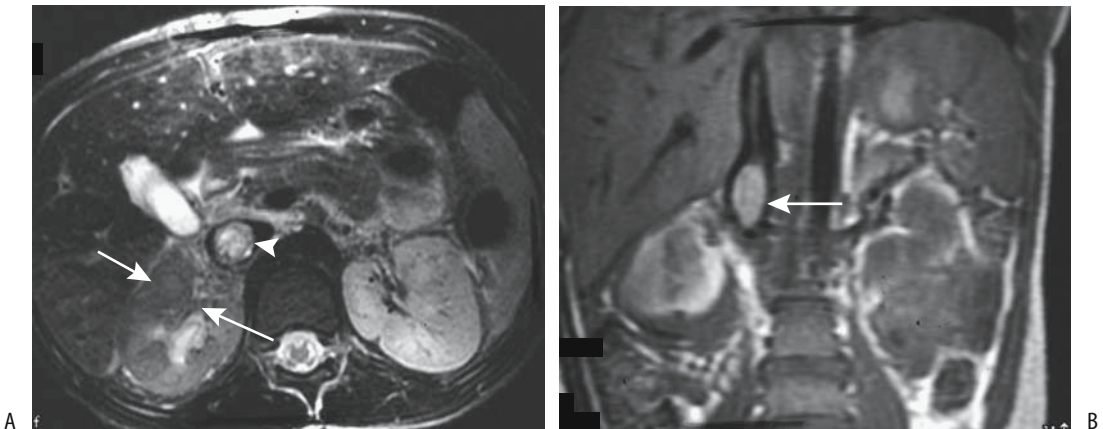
Wilms' tumor. A: T2-weighted transverse MR image identifies a right renal tumor (arrows) with extension into the renal vein (arrowhead). B: Coronal T1-weighted image shows tumor extension into the vena cava (arrow). (Source: Burgener FA, Meyers SP, Tan RK, Zaunbauer W. *Differential Diagnosis in Magnetic Resonance Imaging*. Stuttgart: Thieme, 2002, with permission.)
